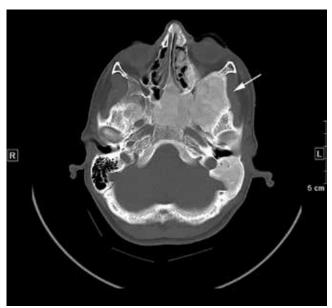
Axial computed tomography shows "ground-glass" opacity of the bones at the base of the skull, including the left maxillary sinus, left sphenoid bone, and mastoid portions of both temporal bones (arrow). This is consistent with polyostotic fibrous dysplasia.
